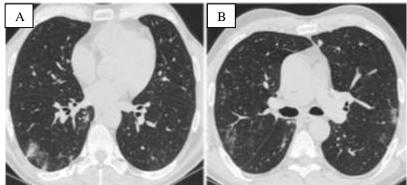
HRCT lung window images showing multiple segmental consolidations with ground-glass opacities in subpleural and peribronchovascular regions.
